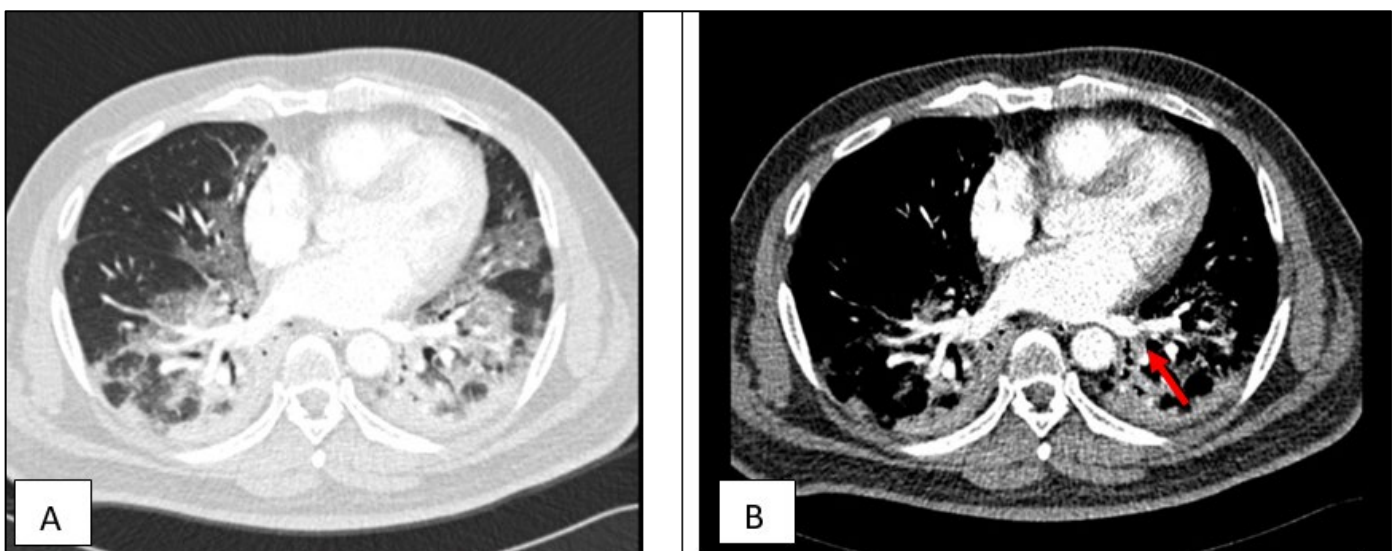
Selected CT Thorax demonstrating (A) lung injury with organizing pneumonia and (B) Left basal subsegmental PE (red arrow)
